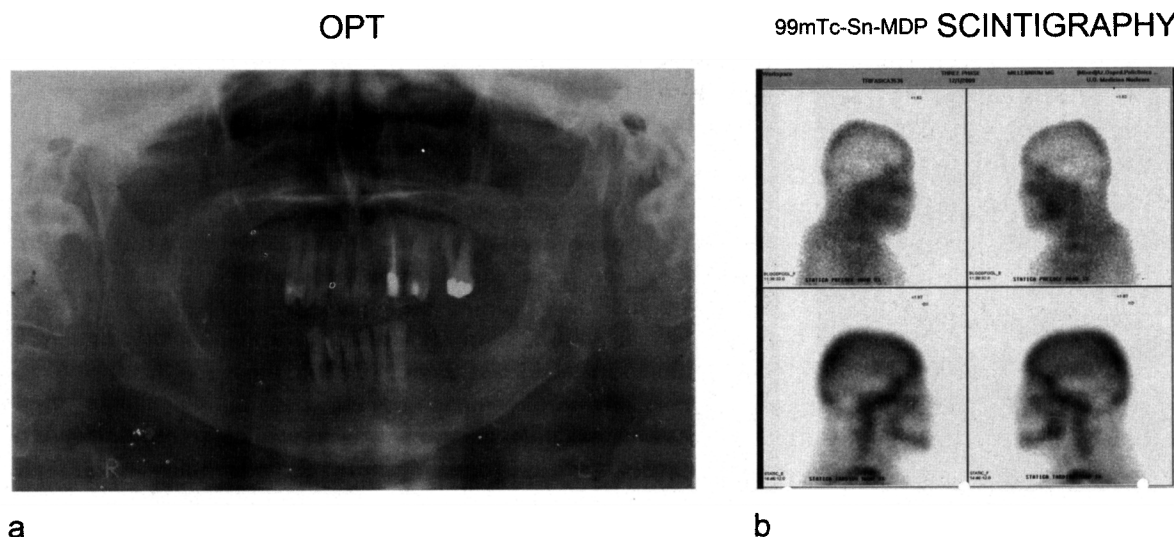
a) Panoramic radiographs (OPT) show severe edentulism. b) $^{99m}\text{Tc-Sn-methylidiphosphonate}$ scintigraphy demonstrates increased uptake in the left jaw, one of the typical markers of inflammation.
